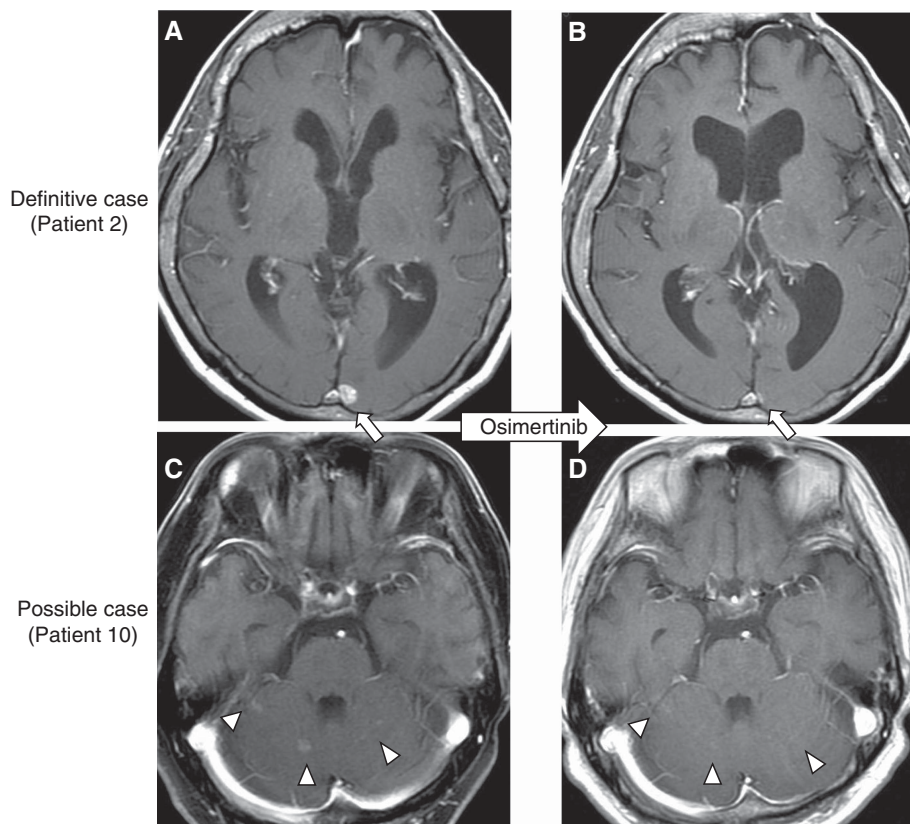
Representative magnetic resonance images before and after osimertinib (patients 2 and 10) Patient 2 (definitive case): (A) before osimertinib and (B) 2 months after osimertinib initiation. Patient 10 (possible case): (C) before osimertinib and (D) 2 months after osimertinib initiation.
